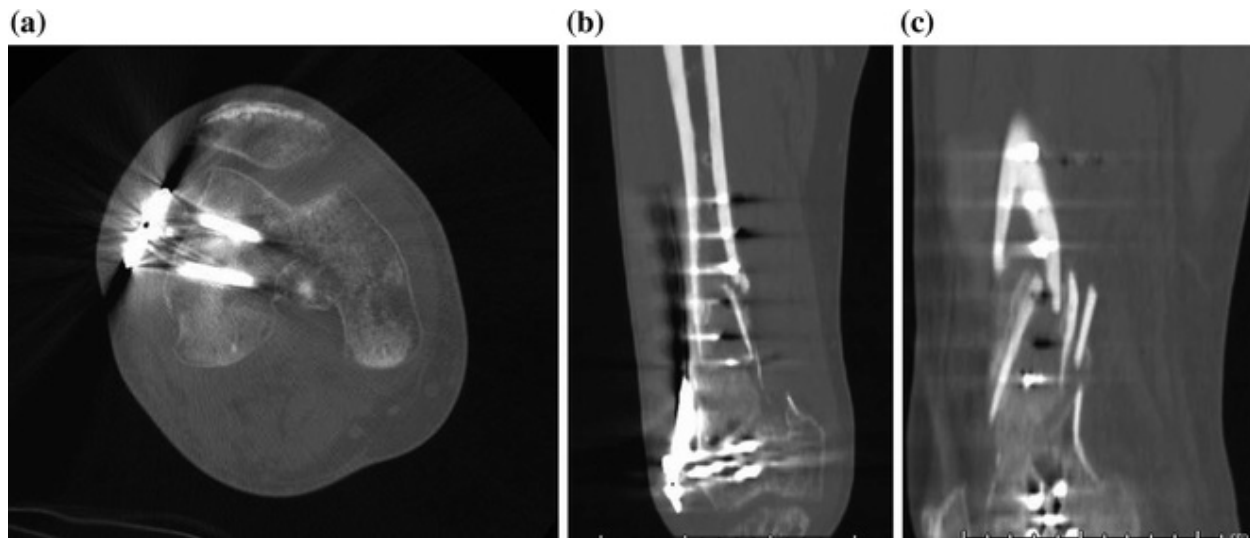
a Axial computed tomography (CT) image showing healing of the intra-articular component; the gap between the plate and the bone is well visualized; b coronal CT image showing the varus alignment, failure of hardware and the metaphyseal nonunion; c sagittal image also showing the nonunion
